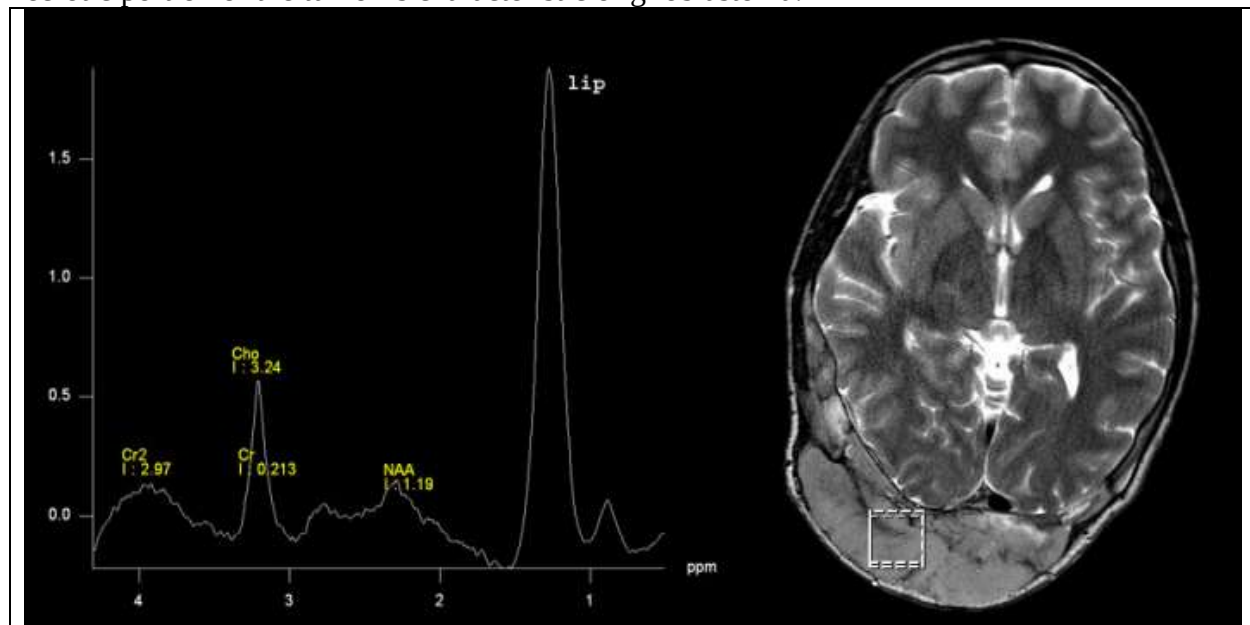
MRI scan of non-Hodgkin's lymphoma with occipital bone involvement. The tumor has a significantly elevated lipid peak. The MRI image on the right shows the data collection site.
